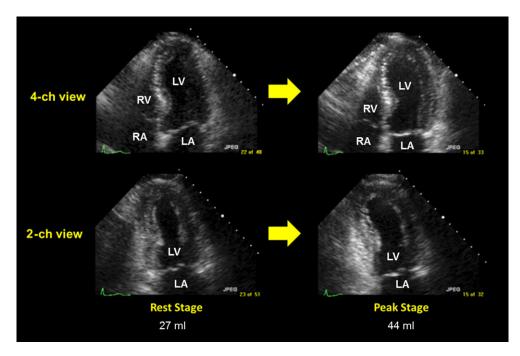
Example of systolic transient ischemic dilatation (TID_{ESV}). End-systolic frames of the LV apical four-chamber views (top) and apical two-chamber views (bottom) at baseline (left) and peak stress (right). LV end-systolic volume increased by 63% at peak stress compared with baseline in this case. 4-ch = apical four-chamber; 2-ch = apical two-chamber; RV = right ventricle; RA = right atrium; LV = left ventricle, LA = left atrium.
